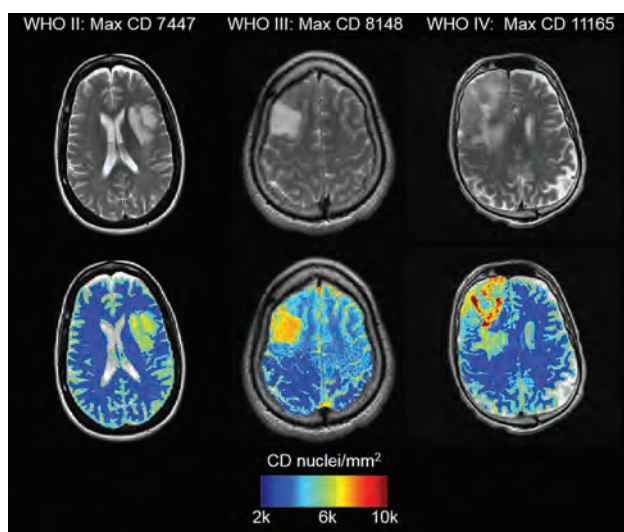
Maps of estimated CD for gliomas of known WHO grades. T2-weighted images are shown in the upper row for reference. Note the graphic nature of CD estimates and how CD maps can be used for image-guided therapy.
